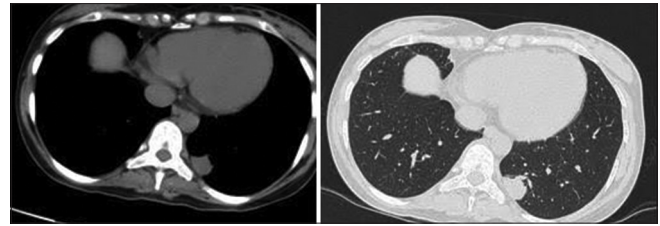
High-resolution computed tomography chest showing solitary pulmonary nodule of the left lower lobe in both mediastinal and lung window
